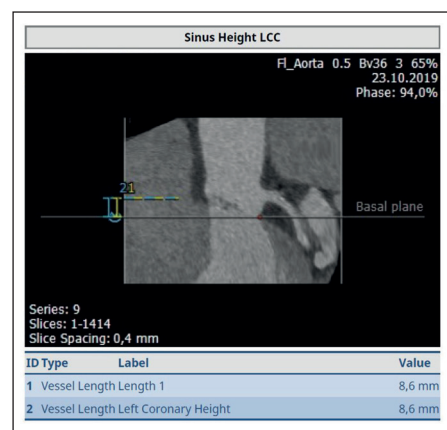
TAVI-CT revealed a low height of 8.6mm for the left main.
